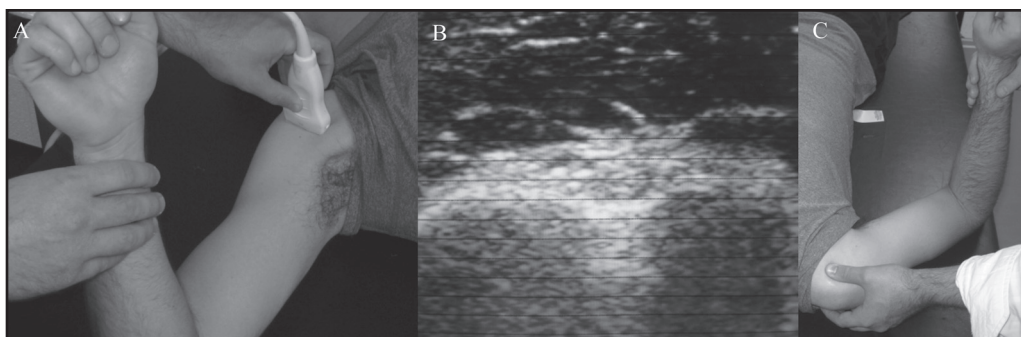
Transducer placement (A) and reference grid (B) for ultrasound measurement. Palpation placement (C) for clinical examinations
